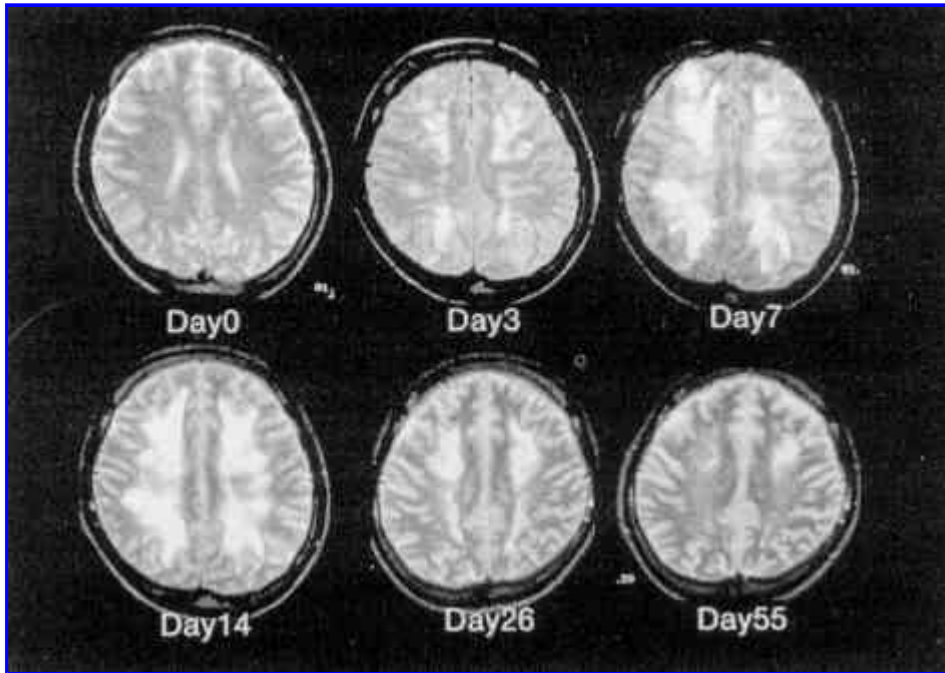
Serial MRI-T2WI in case 1. MRI-T2WI performed 4 hours after onset of neurologic symptoms (day 0) show small, high-intensity lesions in the deep white matter (MRI grade 1). The number of high-intensity spots increased and fused on T2WI obtained at day 3 (MRI grade 2). The lesions progressed until they peaked at day 14 (day 14) (MRI grade 3). By day 26, the lesions diminished (MRI grade 2) (day 26), but still remained as focal infarctions in MRI performed on day 55 (day 55).
